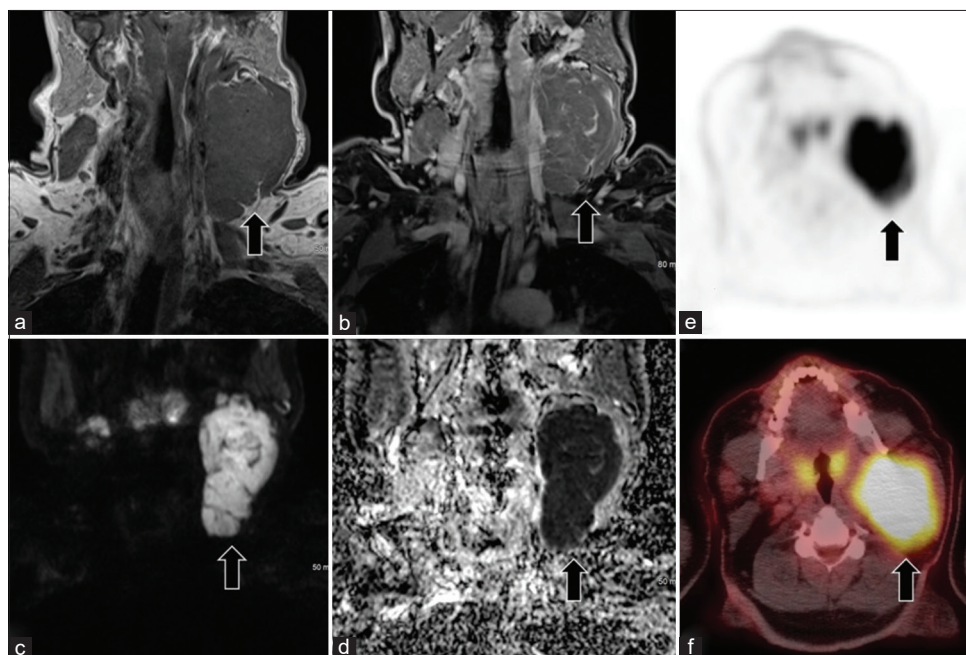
Left carotid space diffuse large B cell lymphoma in a 65-year-old male. Coronal T1 (a) and T1 with fat saturation after IV gadolinium administration (b) showed large lobulated mildly enhancing mass within the left carotid space medially displacing and compressing the left internal jugular vein (arrows). The mass has significant predominantly homogeneous restricted diffusion on diffusion weighted image (c), and ADC (d). Axial PET (e), and fused PET/CT (f) images demonstrated significant hypermetabolism of the mass with increased FDG uptake (arrows).
